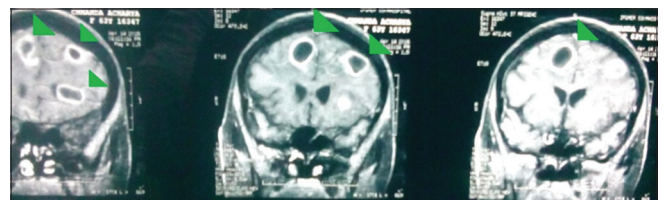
Magnetic resonance imaging brain with contrast (coronal section) shows multiple ring-enhancing smooth margin cystic lesions surrounded by edema in both frontal lobes, suggestive of cerebral abscess
